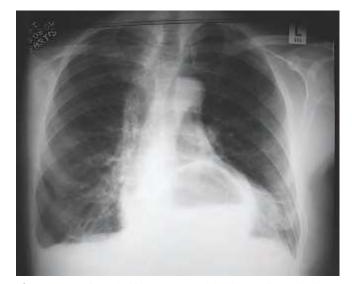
A gas bubble seen on a plain chest radiograph, showing the fundus of the stomach in the chest (courtesy of Dr Stephen Ellis, Bart's and the London NHS Trust).
